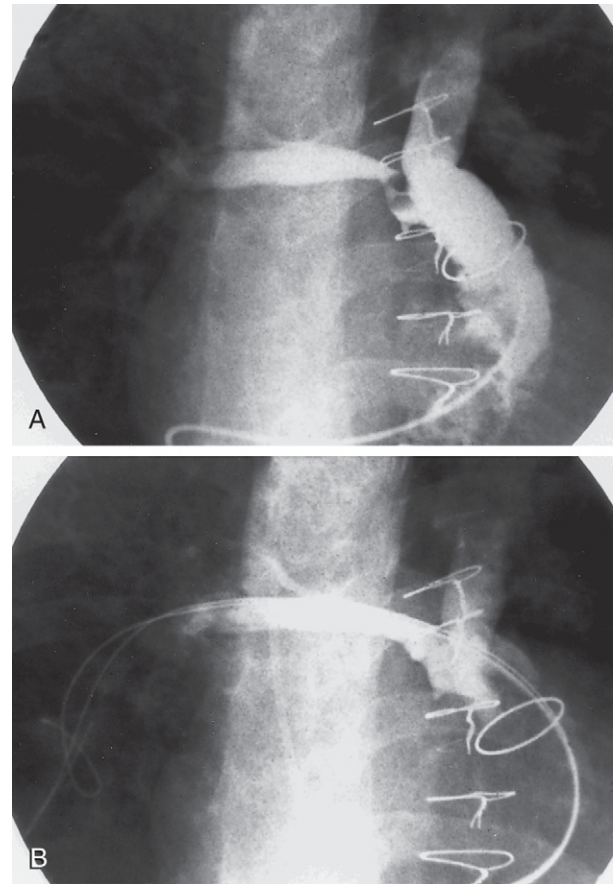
High-pressure balloon dilation of postoperative proximal RPA stenosis (A) leads to elimination of gradient, increased angiographic vessel caliber (B), and resolution of flow imbalance by nuclear lung scintigraphy. In (A), catheters and wires are placed via the IVC (off the bottom of the angiograms) through the right atrium (from leftward and inferior) through the right ventricle (vertically and superior) and right ventricular outflow to the distal pulmonary arteries. Contrast fills the main and proximal branch pulmonary arteries. At the junction of the sternal wires and the horizontally imaged right pulmonary artery, lack of opacification represents postoperative proximal right pulmonary artery stenosis in this patient. High pressure balloon dilation was performed, and the proximal branch pulmonary arteries are reimaged (B), showing resolution of the stenosis, with continuity of contrast opacification. The gradient was eliminated and vessel caliber was increased.
